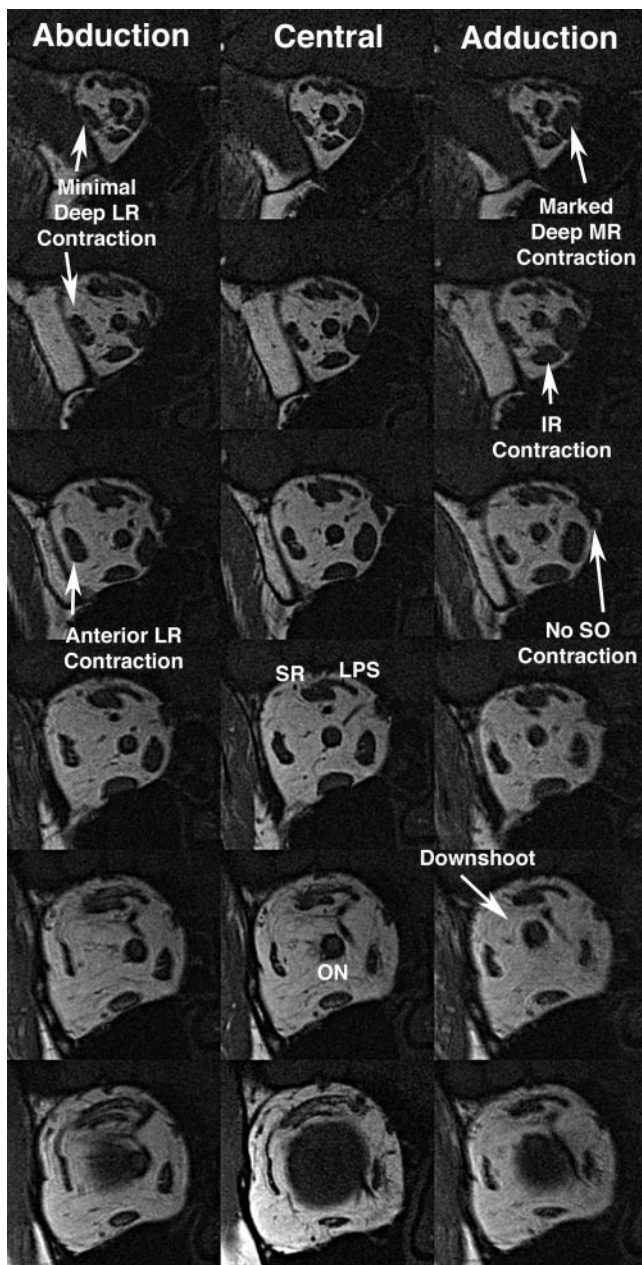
Coronal MRI of the right orbit of subject 1 with the clinical phenotype of unilateral DRS type 3 on the right. Image planes 2-mm thick spaced by 2 mm, resolution 312 μm in planes arranged from posterior at top to anterior at bottom. Fixation was by the clinically normal left eye. Note the minimal increase in the deep LR cross section on abduction, with a moderate increase in the anterior LR cross section on abduction. Although the deep MR exhibited a marked contractile increase in cross section, the eye adducted little, and the elevated position of the globe-ON junction indicated a downshoot. Note the increase in IR cross section in adduction suggestive of IR contraction, without corresponding increase in SO cross section. Note the normal positions of the MR and LR muscles near the globe-ON junction (*bottom row*), indicating normal stability of the horizontal rectus pulleys and ruling out sideslip as the cause of the downshoot in adduction.
